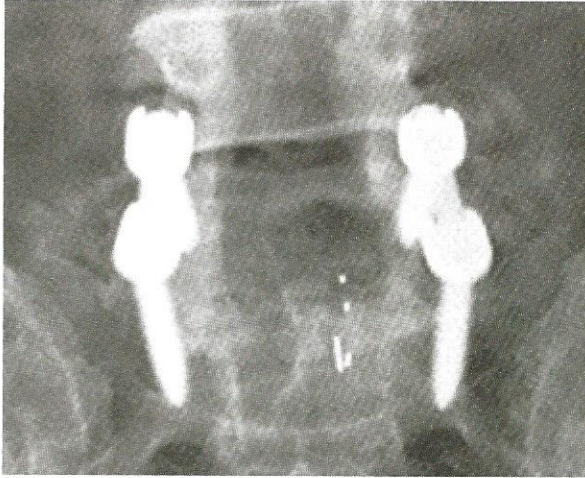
Representative six-month X-ray
